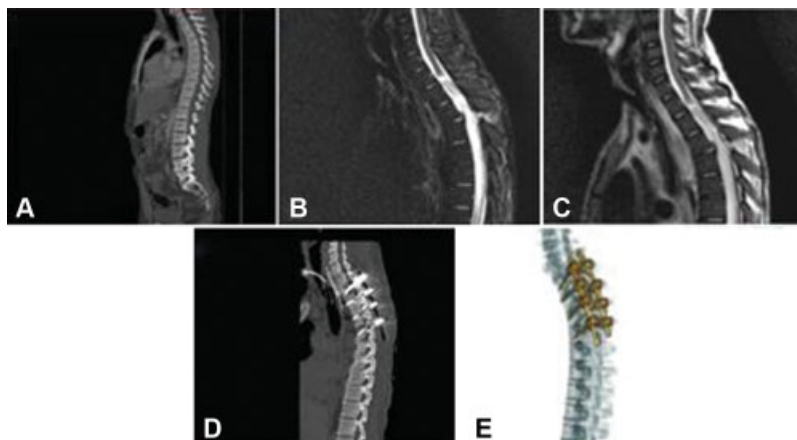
(A) Computed tomography (CT) of the spine at admission, sagittal cut, without evident alterations related to trauma. (B) T2-weighted magnetic resonance imaging (MRI) sequence with fat suppression (short tau inversion recovery – STIR) showing small disc extrusion between T3 and T4, with change in medullary signal and ligamentous injury between posterior elements of T3 and T4. (C) The T2 sequence shows an interspinous ligament hypersignal, suggesting rupture, besides the spinal compressive effect extending from T1 to the medullary cone level. (D) Postoperative control CT of the arthrodesis with posterior instrumentation, fixating 4 levels (T2-T5). (E) Three-dimensional (3D) reconstruction showing the final aspect of the arthrodesis.
